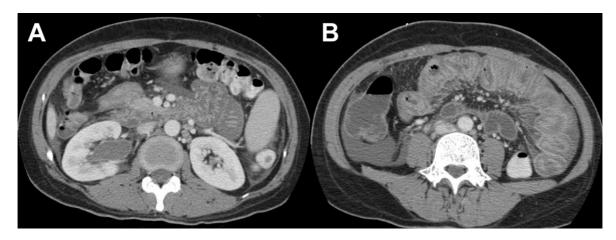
Contrast-enhanced CT scans in a 37-year-old female had GI vasculitis and genitourinary tract abnormality; (A) and (B) CT scans show inhomogeneous circumferential wall thickening at jejunum with mesenteric change, right hydronephrosis is also depicted (A)
